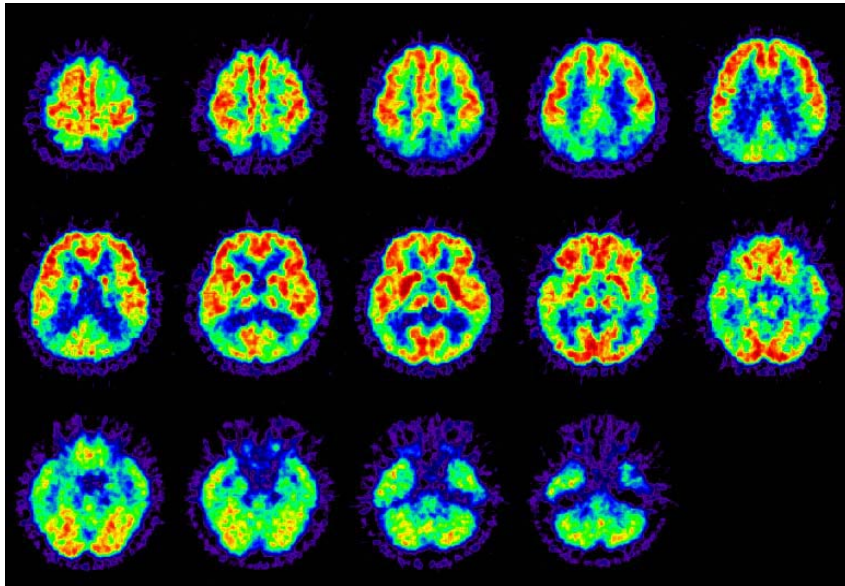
Typical FDG-PET image of a patient with AD. This case is a 52-year-old female whose MMSE score was 19. Typical AD reduction pattern is shown on the axial plane images.
